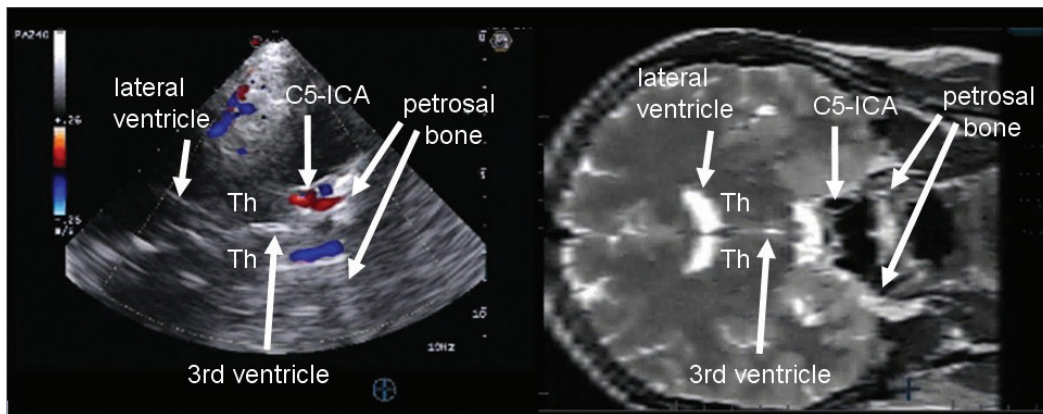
Example of the anterior coronal imaging plane. Ultrasound fusion imaging (UFI) color-mode imaging matched with a T2-weighted MRI dataset of a patient without pathological findings. Note the symmetrical hyperechogenicity of the petrosal bone and the B-mode signal of the third ventricle.
